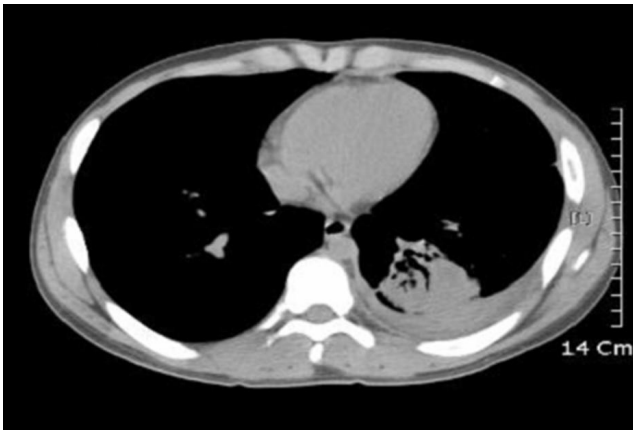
Transverse contrast-enhanced chest CT scan (10-mm collimation) of the 17-year-old male patient obtained after initial detection of pleural effusion shows a 6-cm diameter of alveolar consolidation with small nodules.
